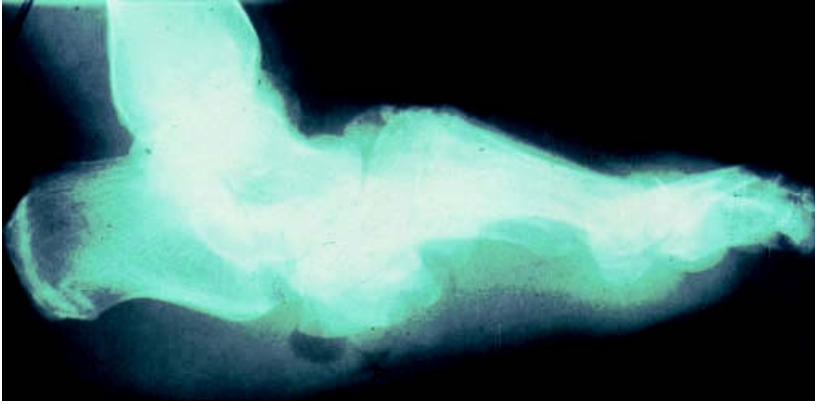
Plain radiograph of a midfoot collapse (collapse of naviculocuneiform, talonavicular and calcaneocuboid joints) due to chronic neuro-osteoarthropathy. Localized bone resorption at the naviculocuneiform joints is also seen
